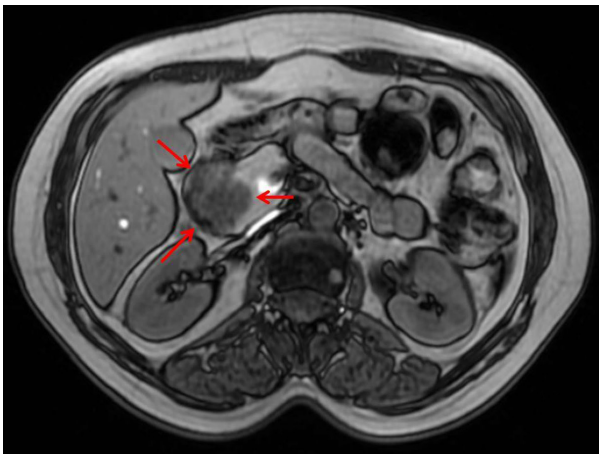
Contrast-enhanced abdominal magnetic resonance imaging shows a mass lesion located in the head of the pancreas, with cystic and solid components, hypointense in T1W, hyperintense in T2W, and heterogeneously enhanced in dynamic studies.
